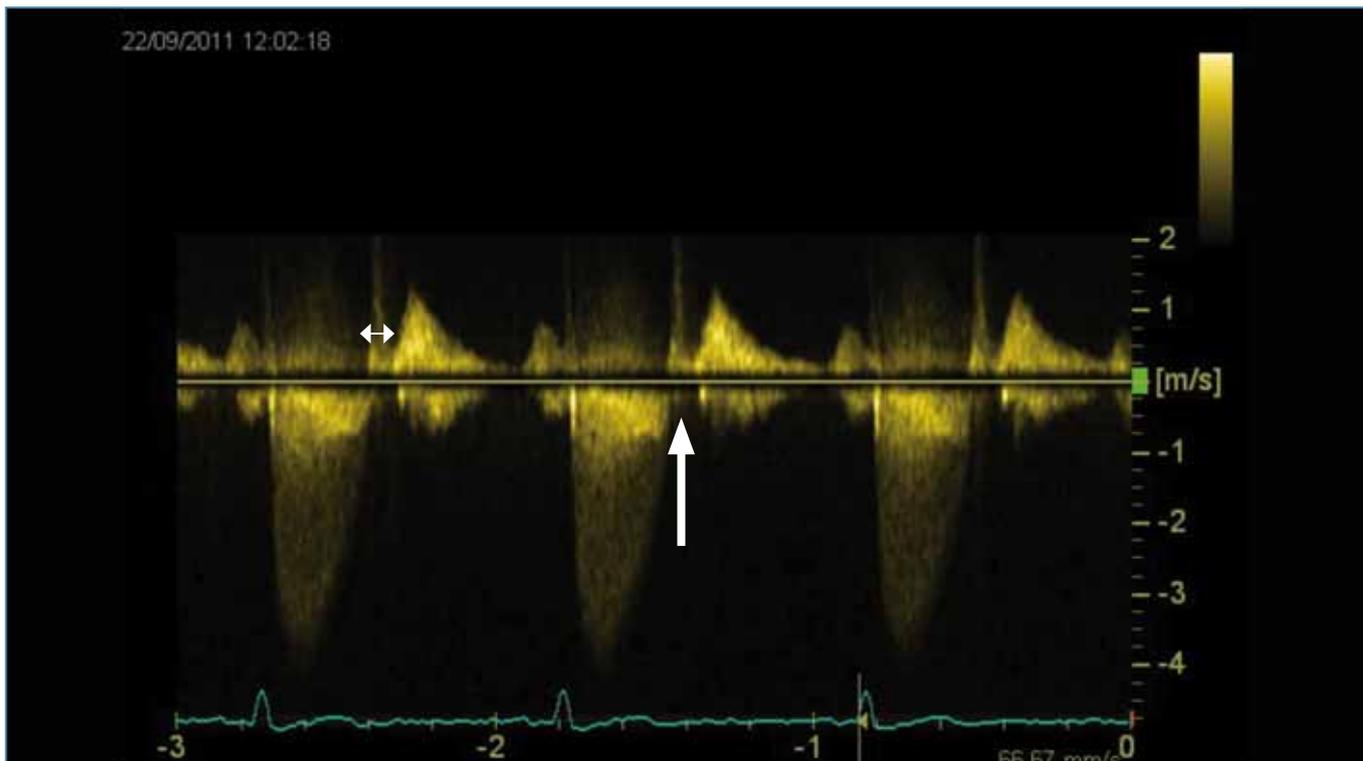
An example of transmitral CW Doppler in a patient with aortic stenosis (AS). The white arrow represents an isovolumic relaxation period between the forward mitral flow and the jet below the baseline identifying this jet as an AS jet.
